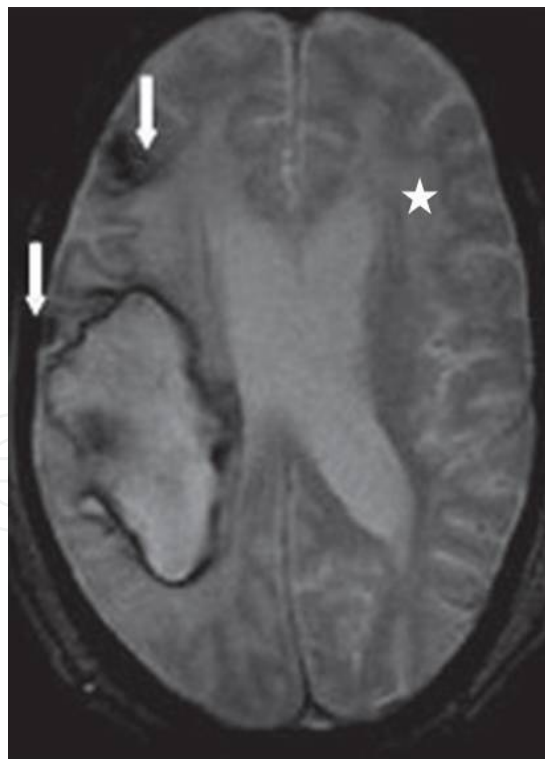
T2*-weighted gradient-echo MR image of same patient as in figure 1, demonstrates a large right parietal hematoma in association with multiple chronic cortical-subcortical microhemorrhages (arrows) and periventricular white matter abnormality (asterisk), thus increasing the probability of CAA.
